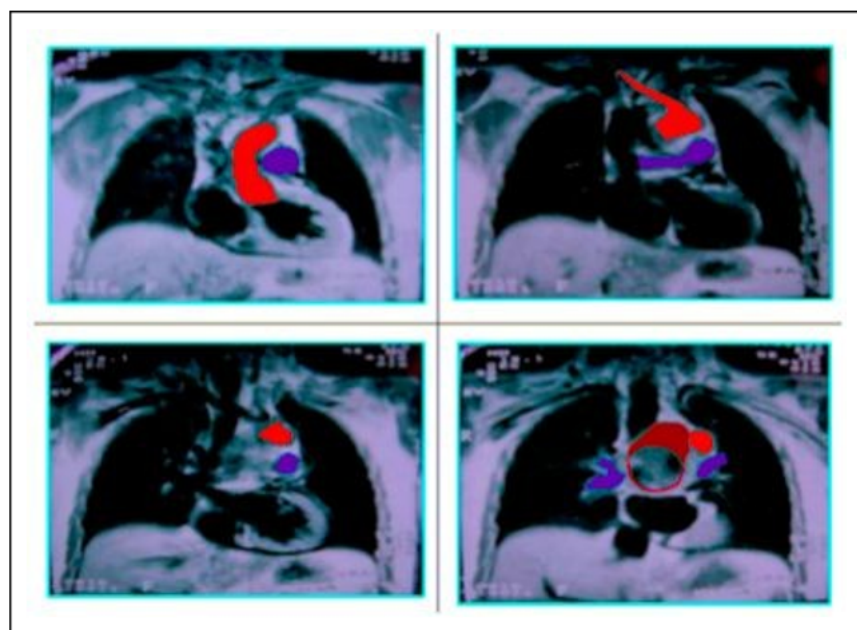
Computed tomography in modified mediastinum window.
